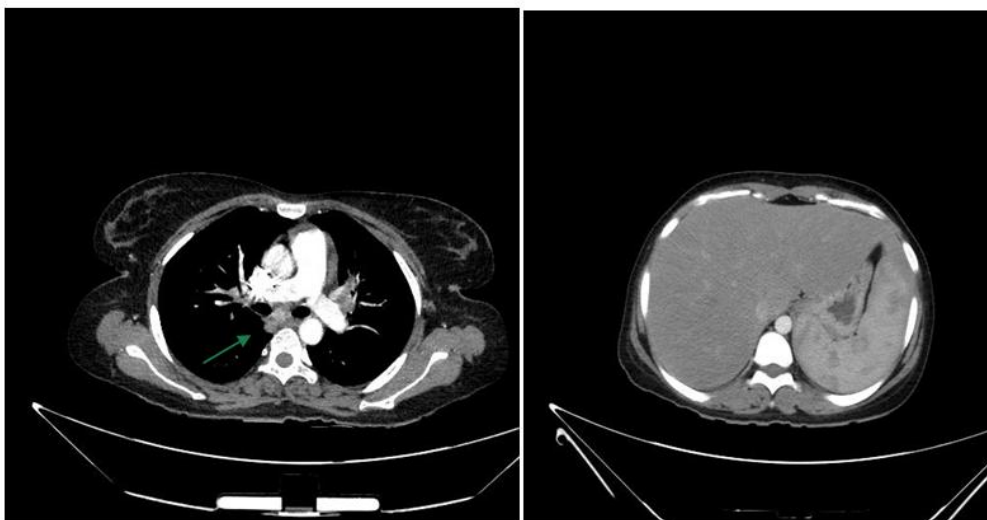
Contrast Enhanced Computed Tomography chest and abdomen showing subcarinal lymph nodes enlargement with enhancement, with other lymph node enlargement and hepatosplenomegaly
